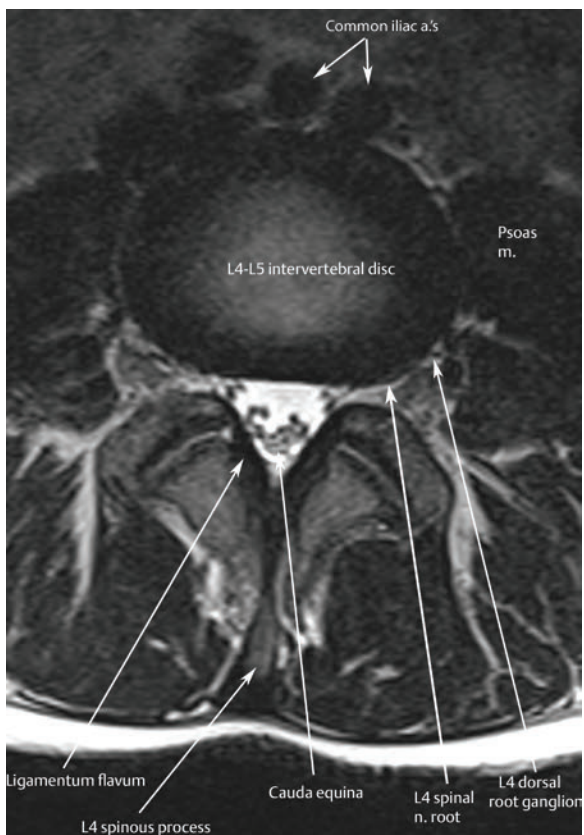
An axial T2-weighted MR image at the level of the L4-L5 intervertebral disc shows the cauda equina, L4 spinal nerve root, and L4 dorsal root ganglion. Normal flow voids are seen within the common iliac arteries, just below the aortic bifurcation.[†]
